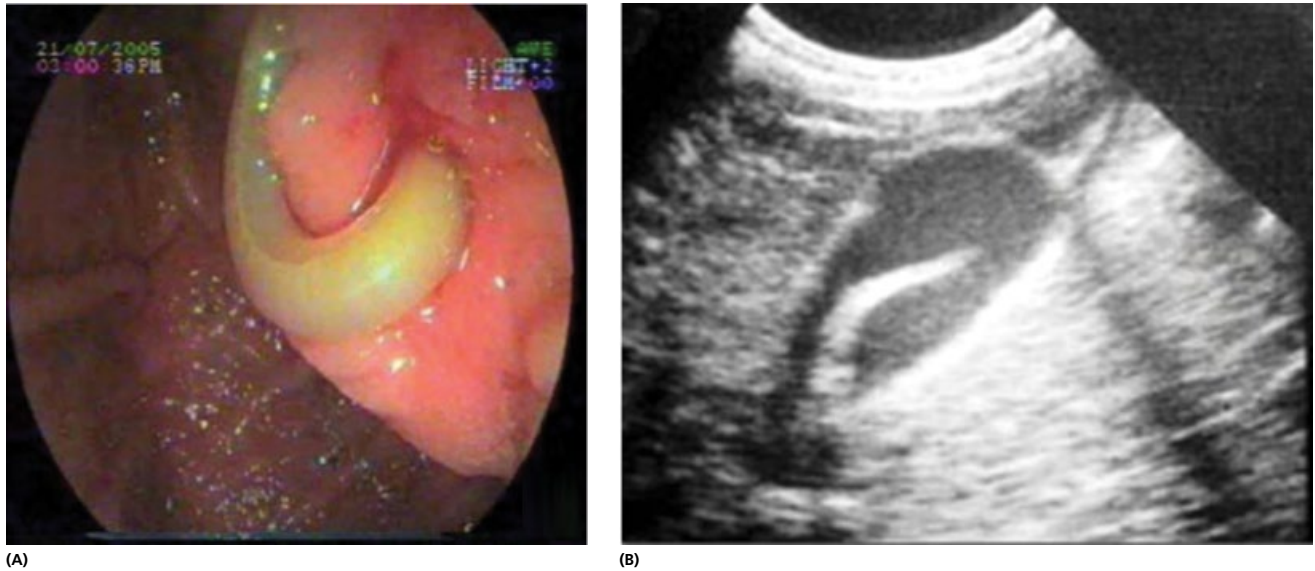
Biliary ascariasis. (A) *Ascaris* worm projecting from the ampulla of Vater on duodenoscopy. (From Ibrarullah *et al.* 2011 [21]. Reproduced with permission of Elsevier.) (B) Ultrasonography showing a linear echogenic filling defect in the gallbladder. (From Anand *et al.* 1999 [22]. Reproduced with permission of Wolters Kluwer Health.)
